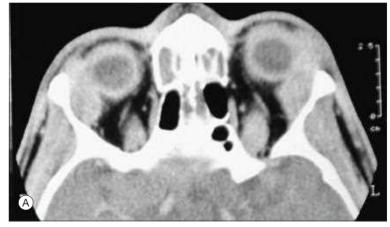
(A) An axial CT scan of a patient with IgG4-related ophthalmic disease (IgG4-ROD) manifesting as bilateral lacrimal gland enlargement. (B) A coronal CT scan of another patient with IgG4-ROD shows bilateral enlargement of several extraocular muscles, patchy infiltration along the left orbital roof, and enlargement of both infraorbital nerves (the left is larger and indicated by the arrow).
